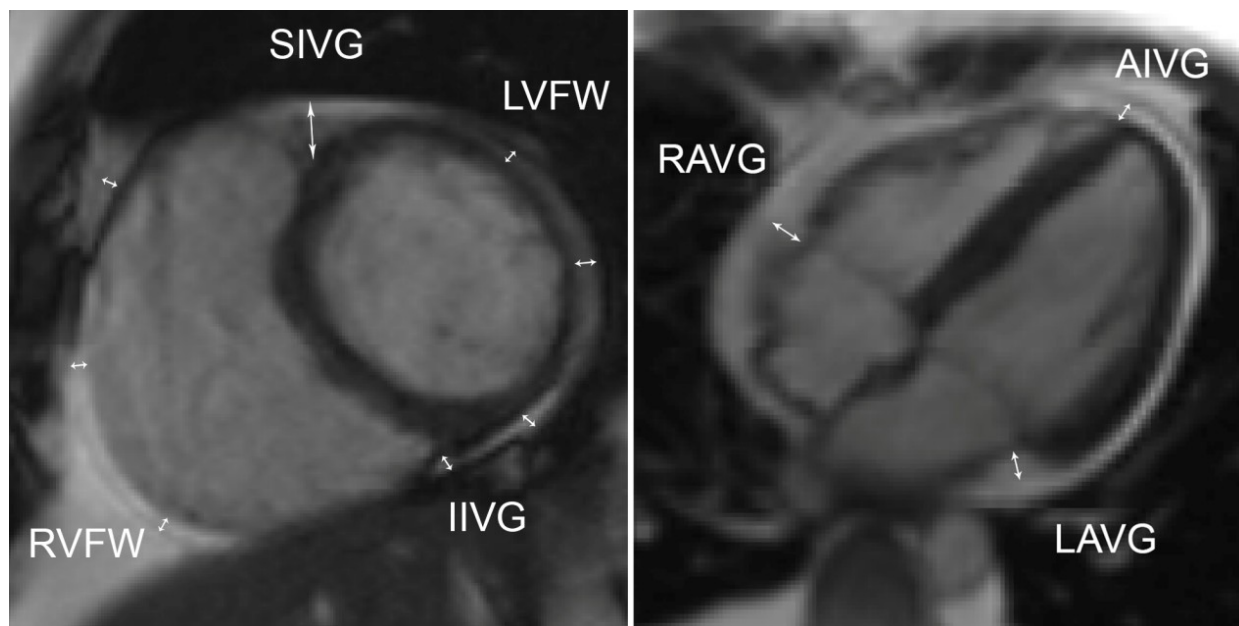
EAT thickness measurement locations using cardiac magnetic resonance imaging: end-diastolic short-axis (left) and long-axis (right) images. LAVG – left atrioventricular groove, RAVG – right atrioventricular groove, AIVG – anterior interventricular groove, IIVG – inferior interventricular groove, SIVG – superior interventricular groove, RVFW (3 locations) – right ventricular free wall, LVFW (3 locations) – left ventricular free wall
